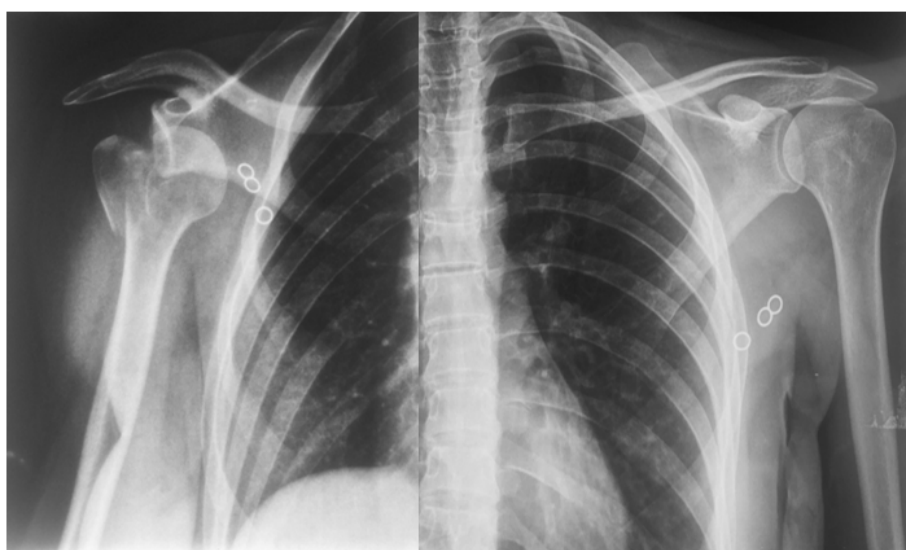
Bilateral shoulders radiograph showing anteroinferior bilateral dislocation with a concomitant fracture of the right greater tuberosity.*
